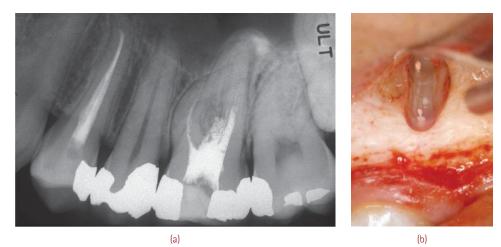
(a) Preoperative radiograph of an endodontically treated maxillary molar requiring endodontic microsurgery. (b) After root resection of all the three roots. (continued)
